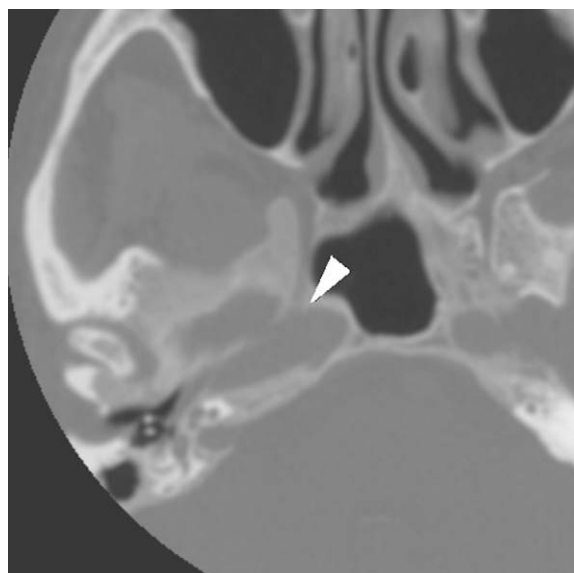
Transverse CT section in a patient with extensive lytic Paget’s disease of the skull base and vault with biochemical and isotope bone scintigraphy features of the disease. Note the lucency on the right petrous temporal bone (arrowhead), basisphenoid, and left petrous apex. Bone thickening and heterogeneity is more typical in the later phases.
